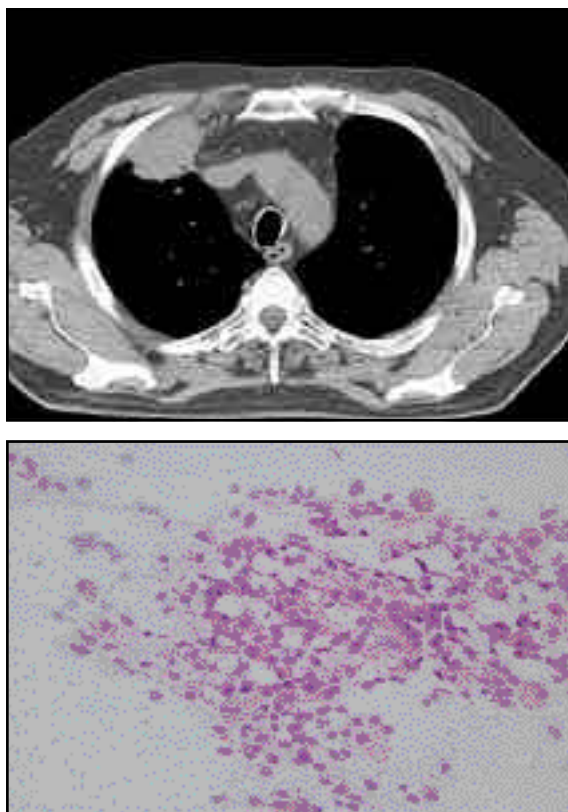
a. A new lesion in the superior lobe of the right lung invading chest wall in the thorax CT in the first year of following (October 2005), b. Diagnosis as adenocarcinoma by transthoracic needle aspiration biopsy, HE X 10
